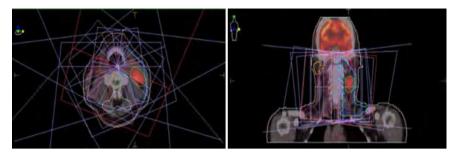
IMRT technique in merged CT and PET/CT image.
